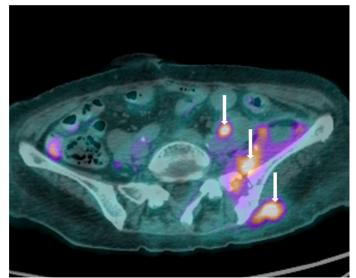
FDG PET study showing areas of increased FDG uptake in the left psoas, left iliacus and gluteal musculature (white arrows) corresponding to the areas of soft tissue enhancement.
